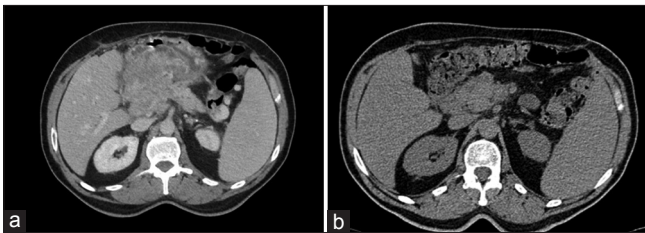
(a) Pretreatment computed tomographic scan showing a wide, irregular, hypoattenuating mass, in the head of the pancreas, with a tumor-like appearance; (b) One month later after antibiotic therapy, computed tomographic scan showing a complete resolution with no more evidence of the mass
